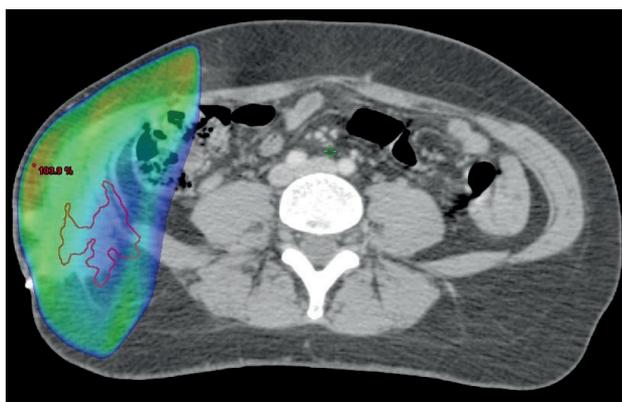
The contoured local recurrence volume in the diagnostic magnetic resonance imaging (MRI) was co-registered with the radiotherapy planning computed tomography (CT) image. The local failure after 50 Gy in 2 Gy fractions definitive radiotherapy was classified as in-target.
